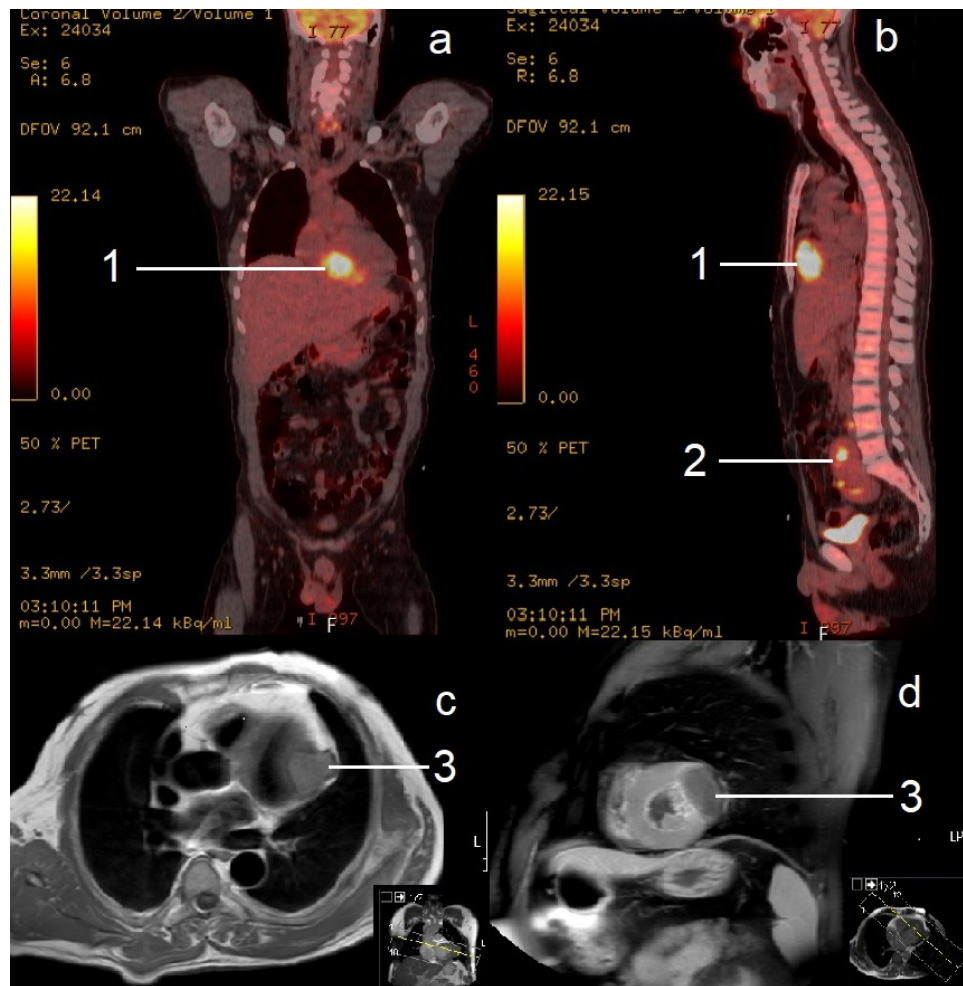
Coronal (a) and sagittal (b) positron emission tomography images of a patient with cardiac (1) and retroperitoneal (2) spread of a testicular tumor. Axial and sagittal magnetic resonance imaging of cardiac cysts (3)
